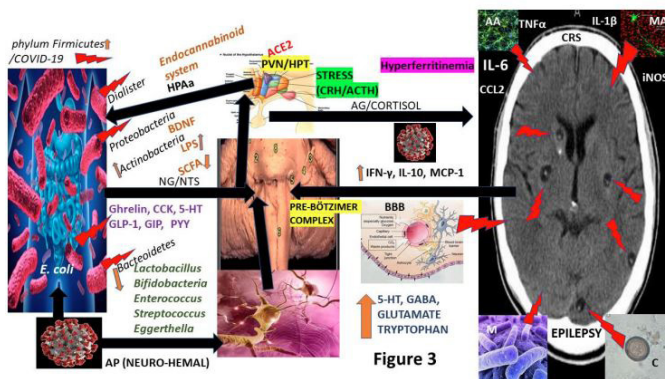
CT scan of the brain axial view: Showing a single cystic lesion in colloid state with surrounding oedema and pathogenesis of hypersynchronous discharge of cortical neurons (ES) in combination with role played by GM/ENS/MO/HPA, CRS, HF, disruption of BBB, SARS-CoV-2/CRS.
